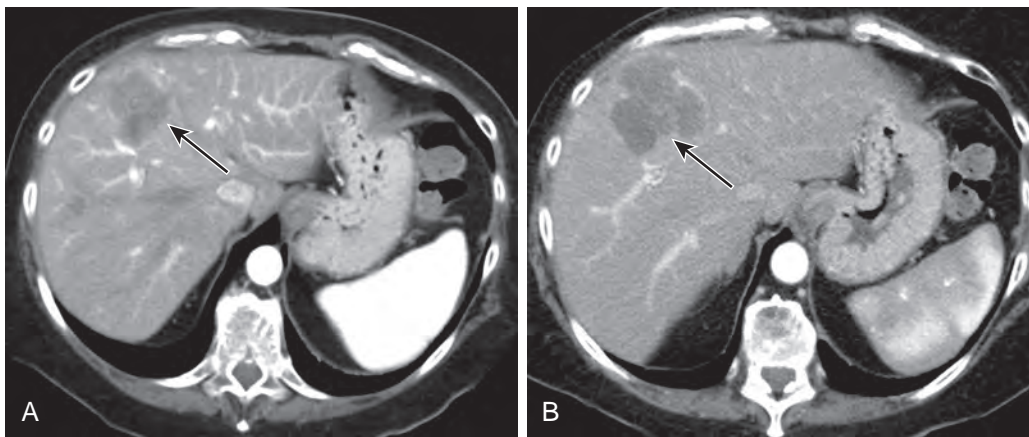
Pitfalls of RECIST 1.1. A 46-year-old man with poorly differentiated hepatocellular cancer. Axial contrast-enhanced CT images before (A) and 1-month after yttrium 90 (^{90}Y) radioembolization therapy (B) demonstrated increase in size of the mass (*arrows*), classified as progressive disease. Follow-up CT scans (not shown) revealed favorable response with decrease in tumor size and enhancement. Tumors treated with targeted therapy, including ablation and embolization, may show initial growth because of hemorrhage and edema.
